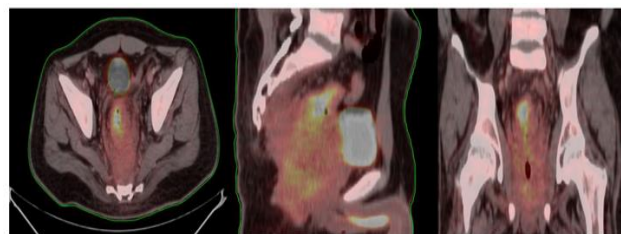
shows the PET CT scan of 23 year old male with adenocarcinoma in axial, sagittal and coronal views
